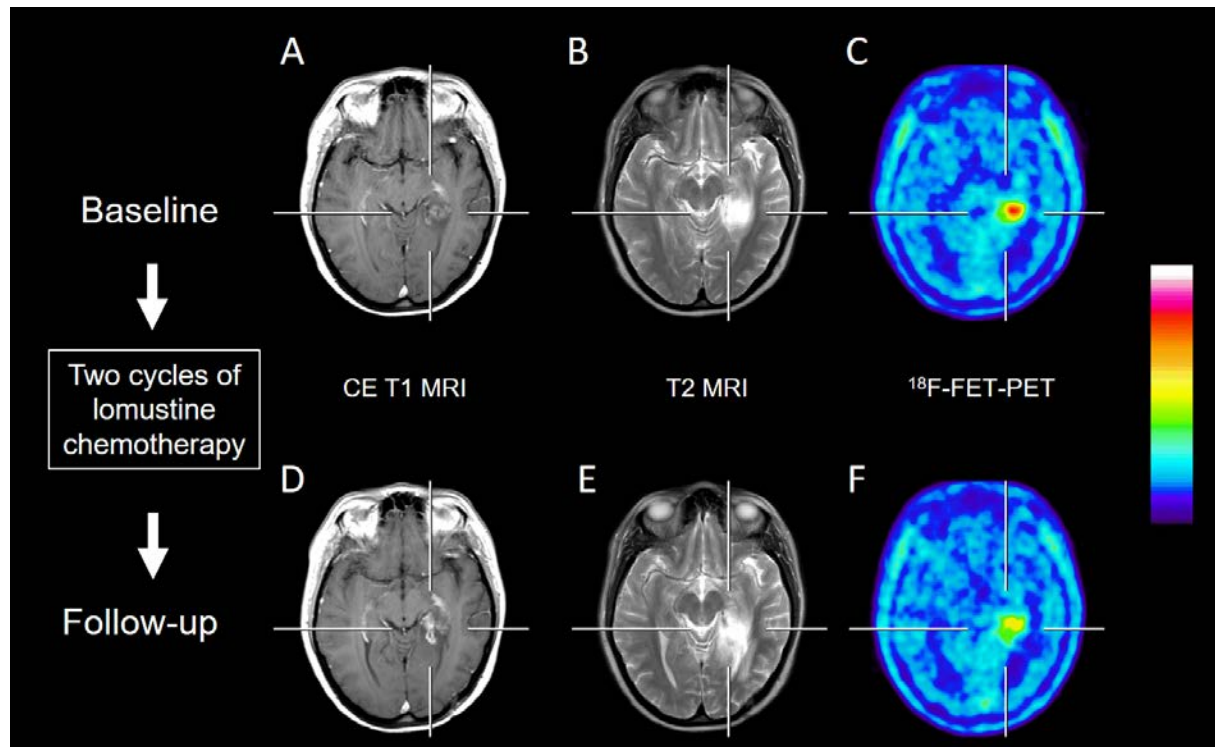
Therapy monitoring in a 31-year-old patient with a recurrent anaplastic astrocytoma in the left parahippocampal region after brachytherapy and radiotherapy with concomitant and adjuvant temozolomide. Contrast-enhanced MRI (CE T1 MRI), T2-weighted MRI and FET PET (A-C) at baseline and 4 months later after 2 cycles of lomustine chemotherapy (D-F). Enlargement of contrast enhancement and the T2 signal suggest tumour progression whereas FET PET indicates a reduction of metabolic activity and response to therapy.
